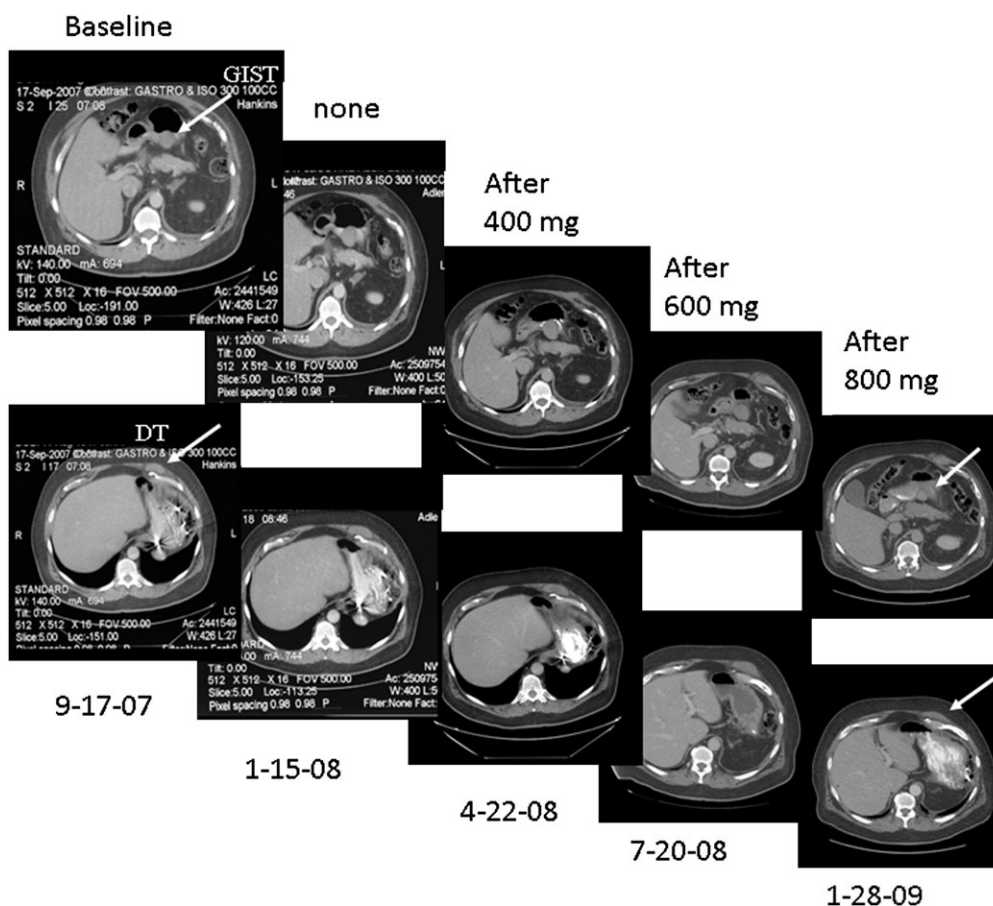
Computed tomography of patient #2 shows that imatinib at 800 mg/day may induce a partial response in gastrointestinal stromal tumor (GIST) and desmoid tumor (DT). Arrows indicate tumor localization.
